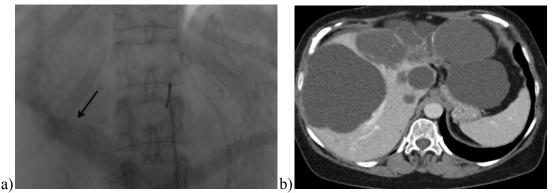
a) CT portography of the hepatic artery b) CT image of the liver cross-section (Coussy et al., 2022)
